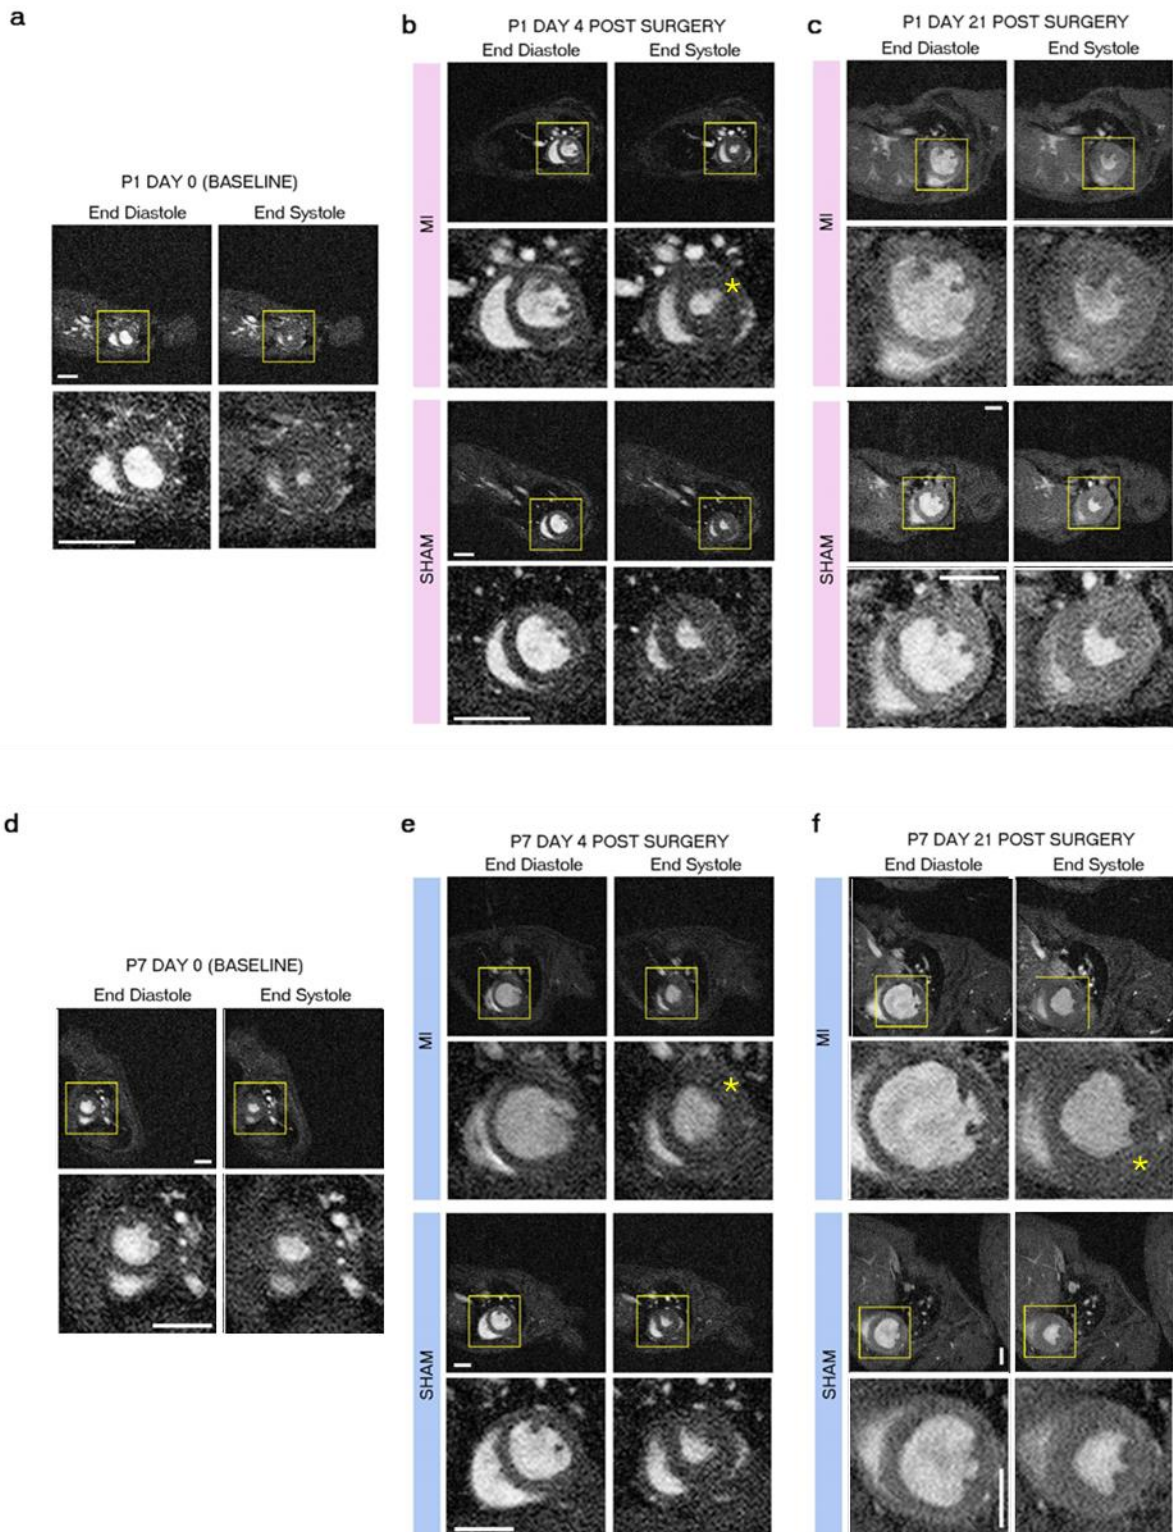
Cine MRI images of P1 and P7 mid-ventricular short axis sections with frames capturing diastole and systole shown for Day 0 (Baseline scan), Day 4 and Day 21 (Endpoint). The top images (a-c, pink bars) are from the P1 cohort with frames after MI compared with Sham directly below; and the same for the P7 cohort (d-f, blue bars) in the bottom half of this panel. It is clearly visible that the P7 after MI has enlarged diastole and systole volumes compared to the age-matched sham, whilst the P1 examples are very similar to each other. Areas of akinesis are labelled by a yellow asterisk in the magnified MI systole images. All scale bars = 2mm
